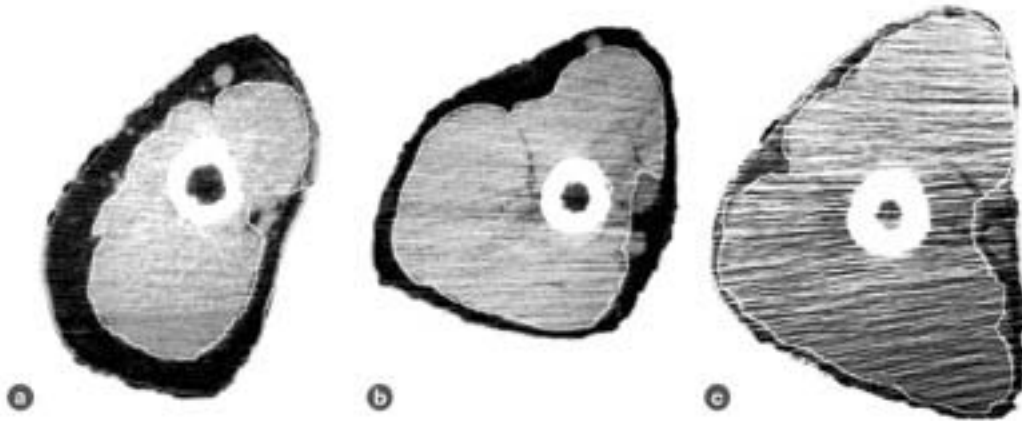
Computed tomography scans of the upper arms of three 57-year-old men of similar body weights. The scans show bone (dark center surrounded by white ring), muscle (striated gray area), and subcutaneous fat (dark perimeter). Note the difference in the muscle areas of (a) the untrained man, (b) the swim-trained man, and (c) the strength-trained man.
